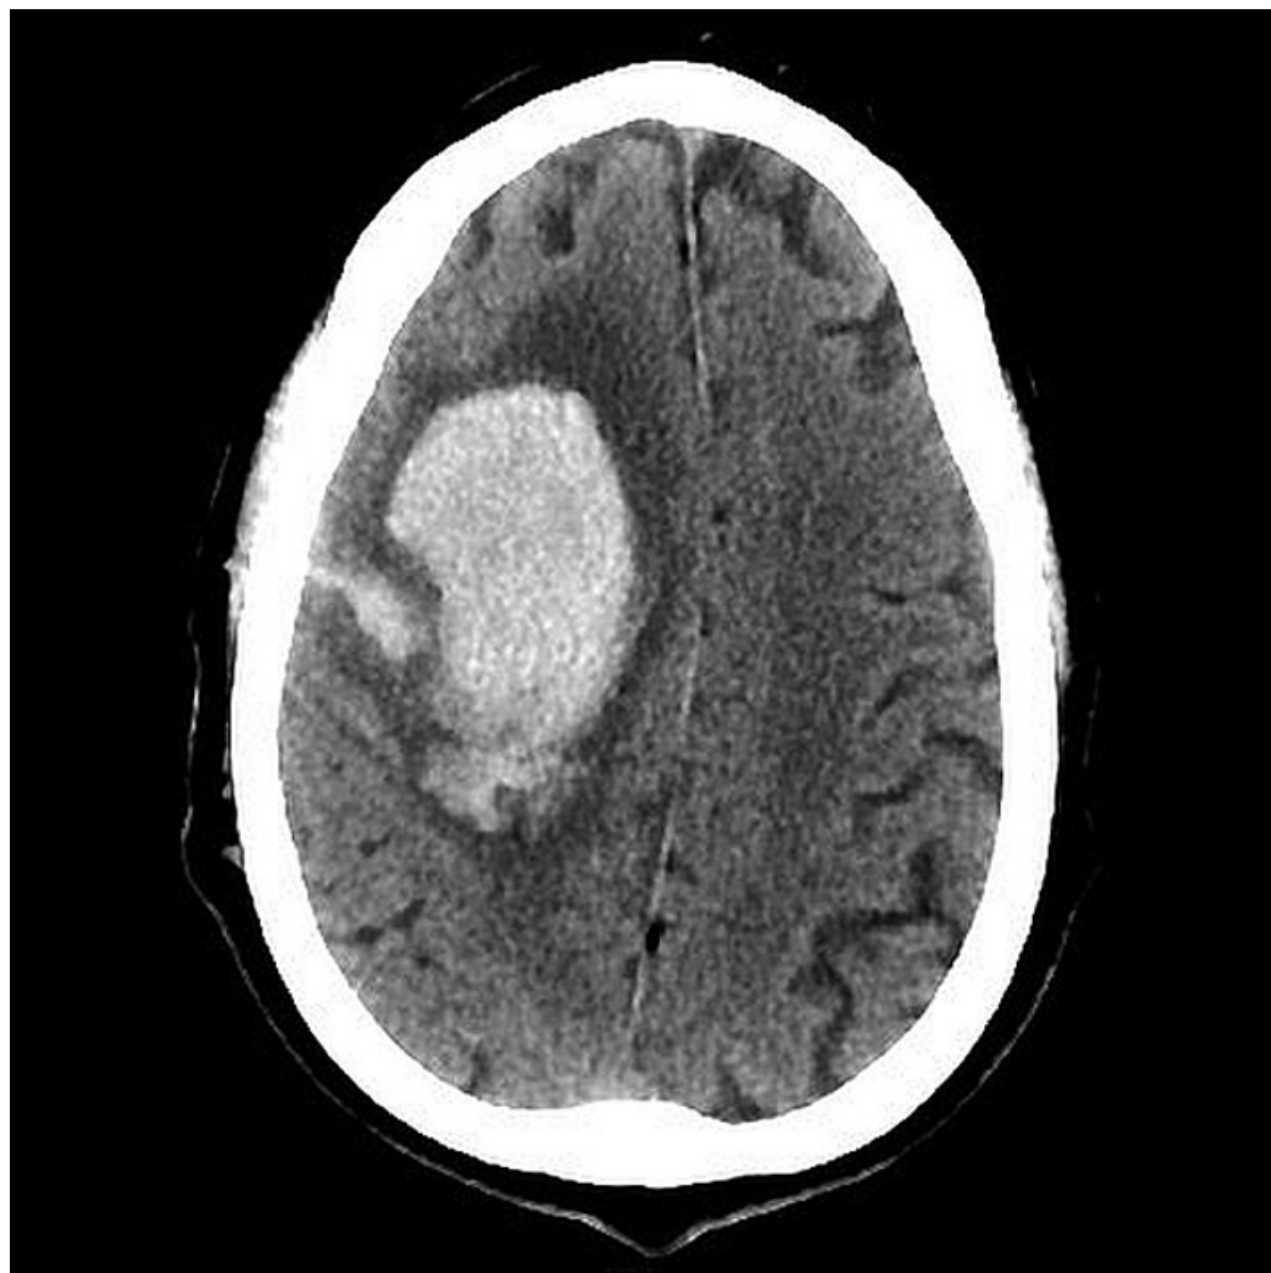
Case example: frontal craniotomy. CT head demonstrating large right frontal intracranial hemorrhage with mild mass effect and midline shift and no hydrocephalus.
